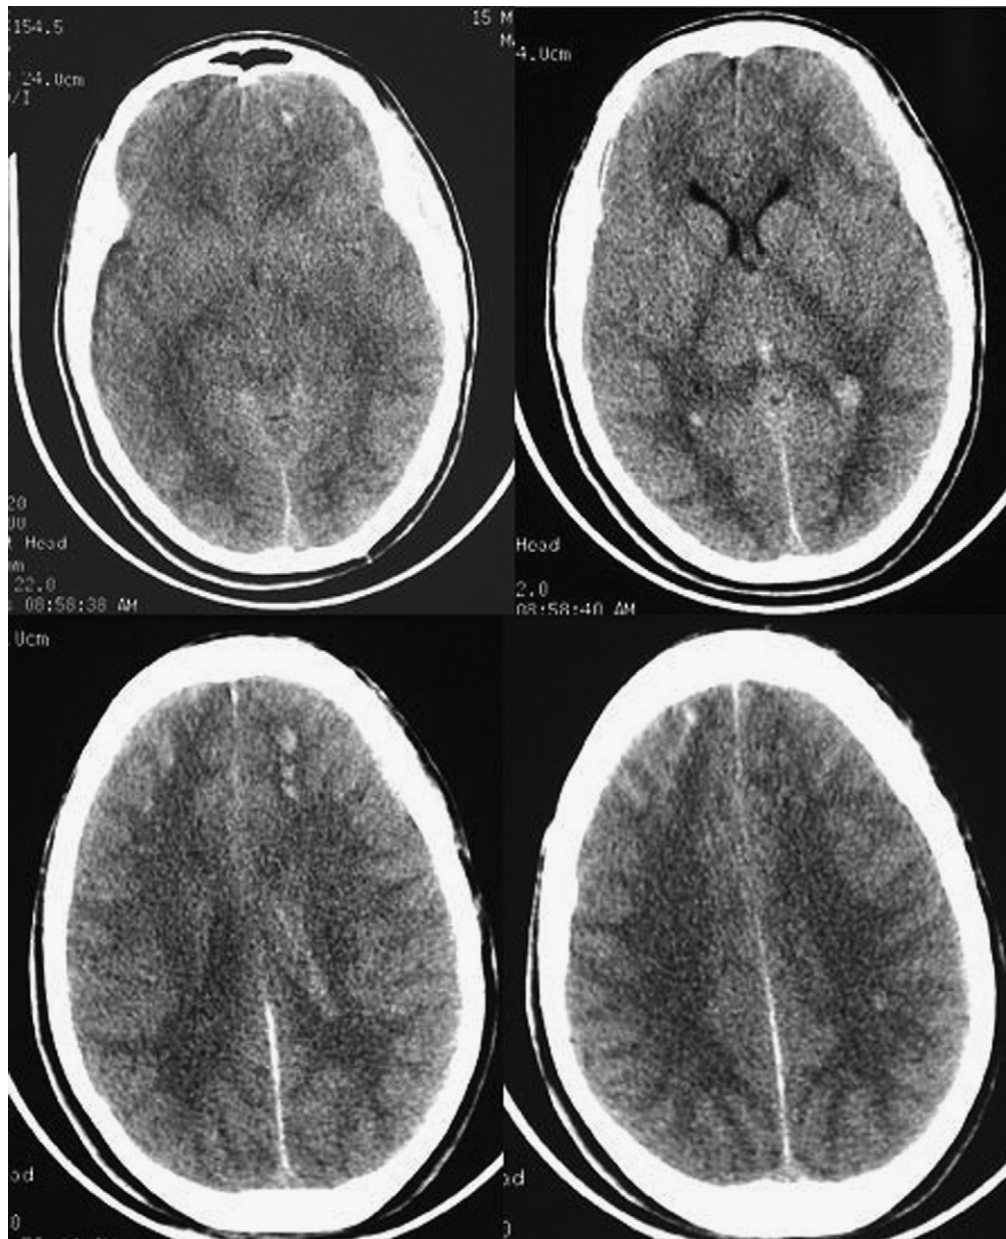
The classical appearance of diffuse axonal injury on an admitting computed tomography (CT) scan. This includes subarachnoid and intraventricular hemorrhages, brain swelling, and small petechial hemorrhages throughout the brain.
